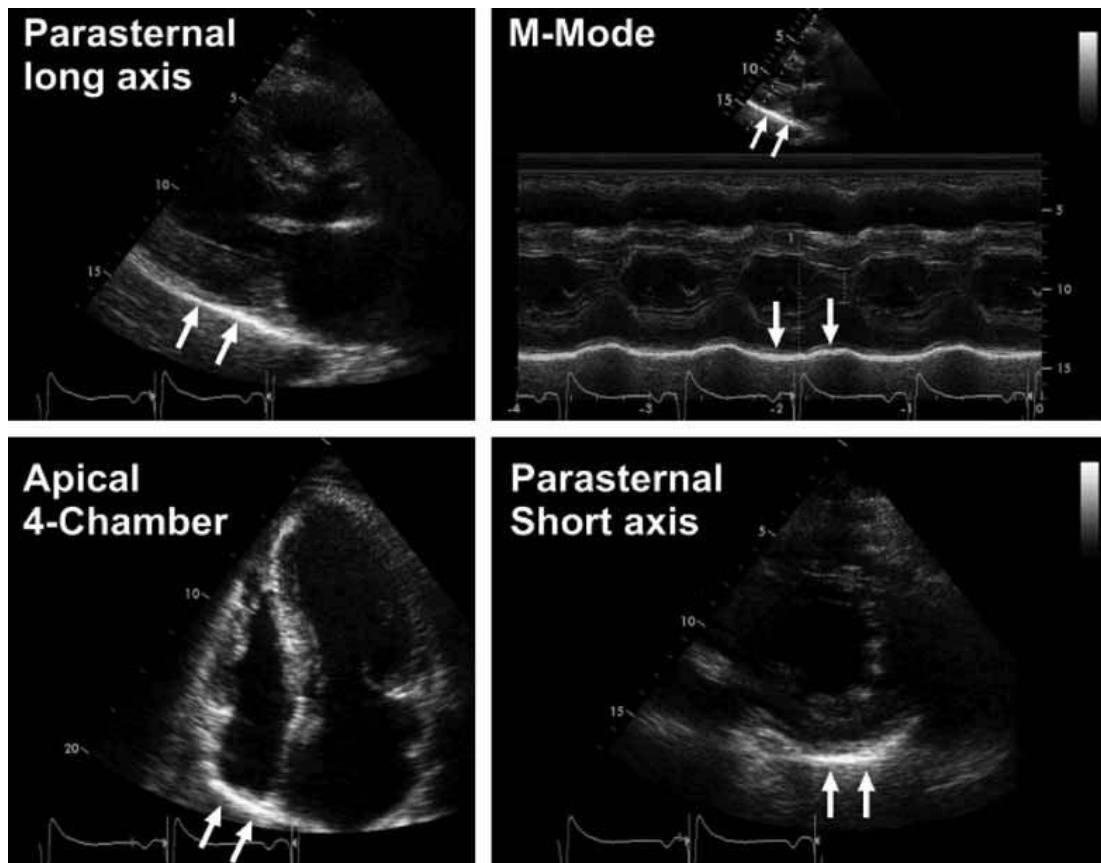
The normal pericardium as shown by transthoracic echocardiogram (Solomon, 2007).
